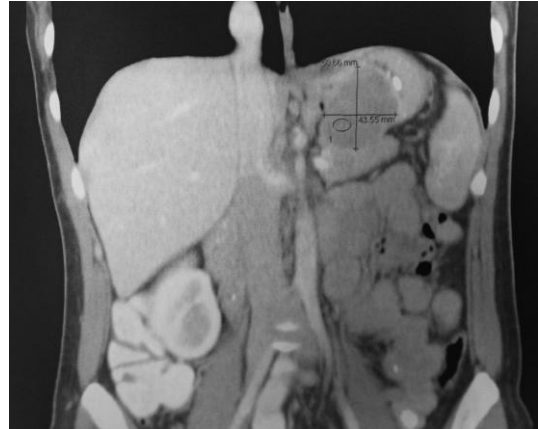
Abdominal CT scan showing LUQ mass.
